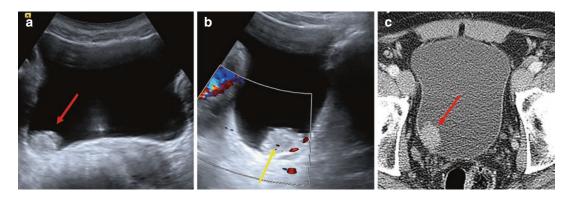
Papillary projection on transverse ultrasound (a, red arrow) and axial CT with intravenous contrast (c, red arrow) compatible with bladder urothelial carcinoma.
